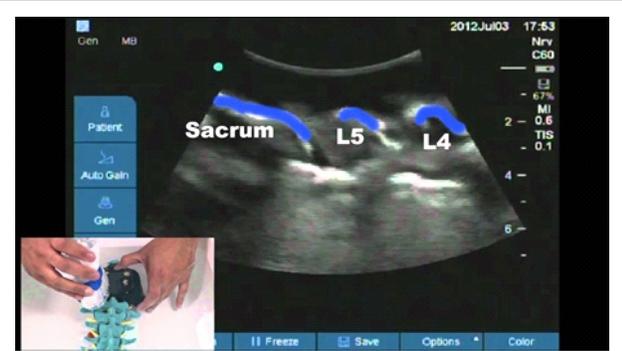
Water bath. Lumbar spine in water bath visualised with ultrasound
